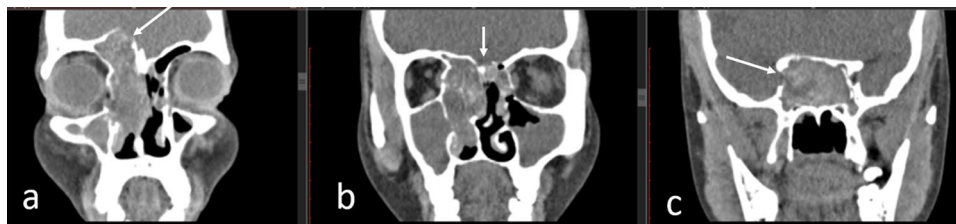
Non-contrast Computed tomography (CT) coronal sections of paranasal sinuses for allergic fungal rhinosinusitis. This CT shows right fovea ethmoidalis erosion (a), left cribriform plate erosion (b) and right lateral sphenoidal wall erosion (c) (All findings depicted by arrows)
